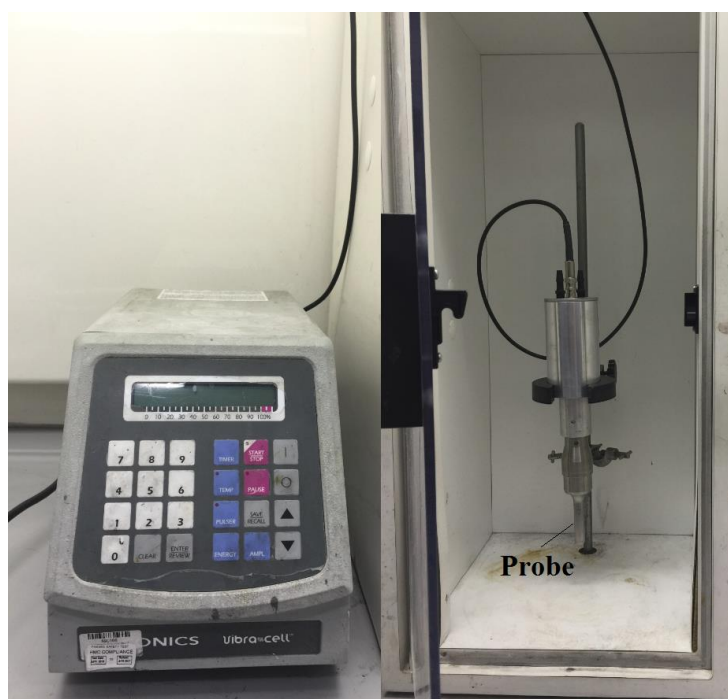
Ultrasonic equipment photographs.
